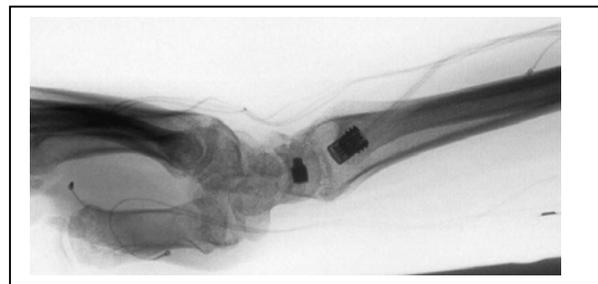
XRay image of implanted IJAT.
